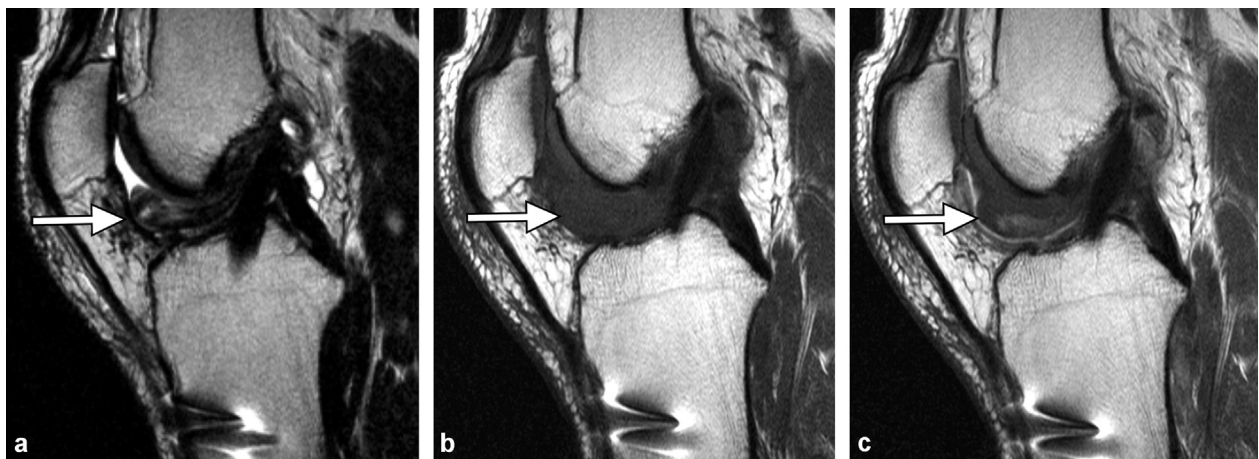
Localized anterior arthrofibrosis (cyclops lesions). Sagittal T2- (a), T1- weighted MR images before (b) and after intravenous administration of gadolinium-chelate (c).
